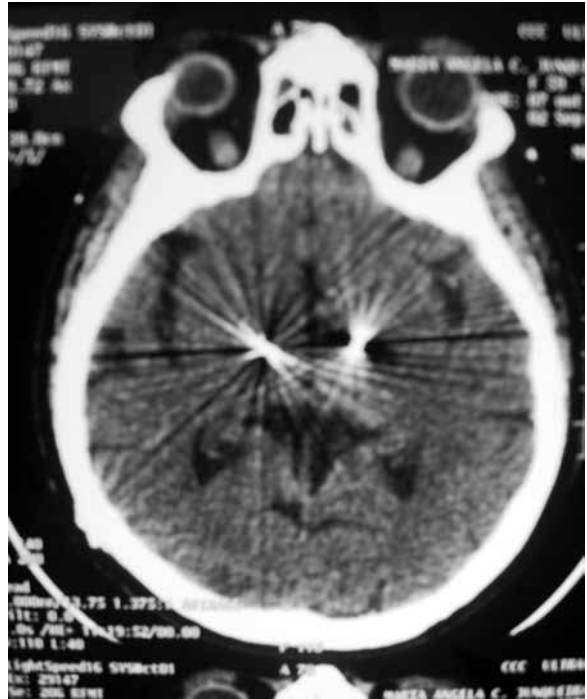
Post-operative computed tomography showing bilateral STN electrodes (DBS).
